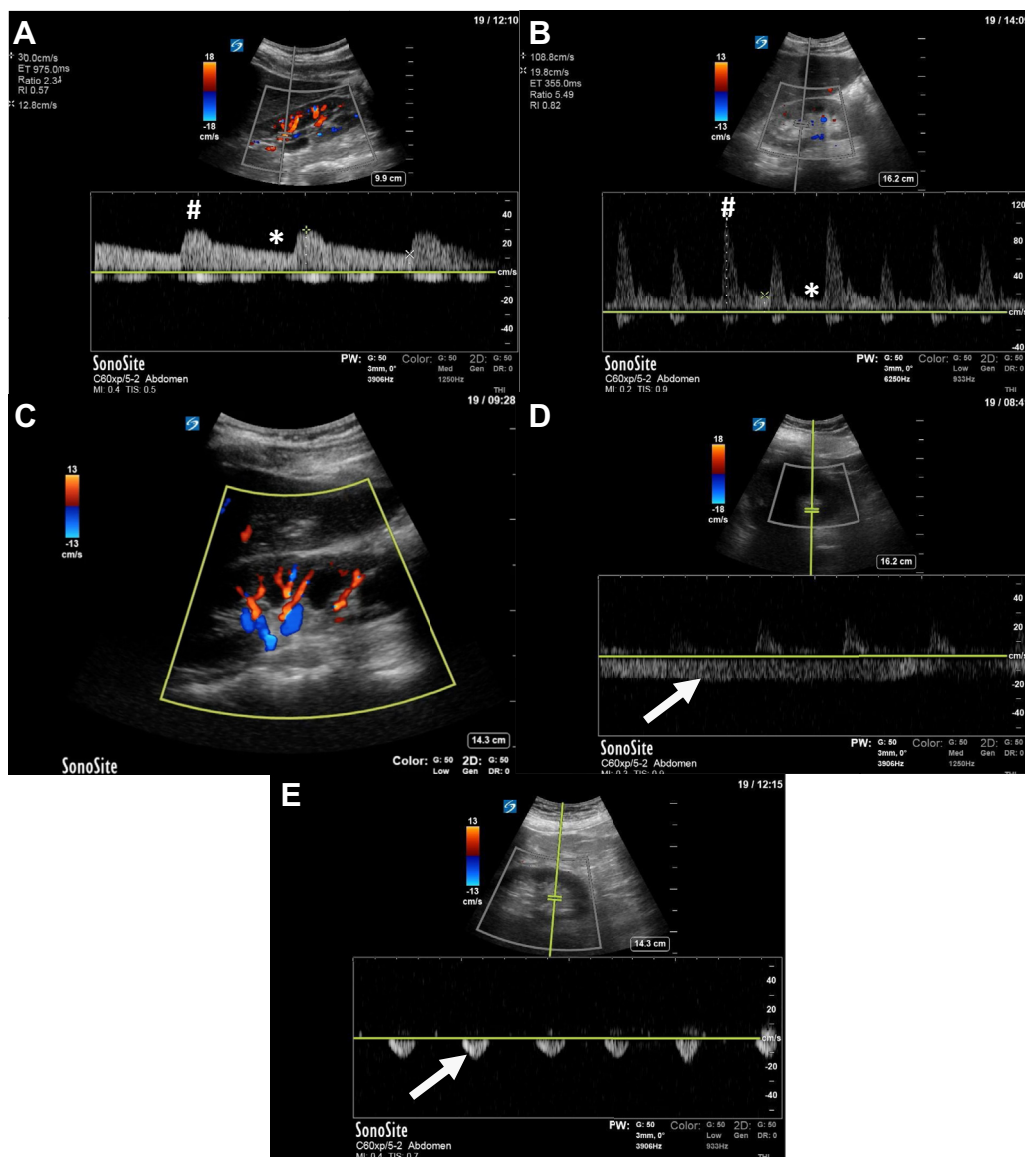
A-E, Renal vascular assessment for congestion. A, Normal intra-renal arterial Doppler waveform, with gentle systolic upstroke (number sign) and preserved end-diastolic flow (asterisk). B, Abnormal intra-renal arterial Doppler waveform with higher velocity in systole (number sign) and lower velocity in diastole (asterisk). C, Kidney in long-axis, with color Doppler to assist in locating vessels. D, Normal intra-renal venous Doppler waveform, with continuous flow below the baseline (arrow). E, Very abnormal intra-renal venous Doppler waveform, with monophasic waveform (arrow).
